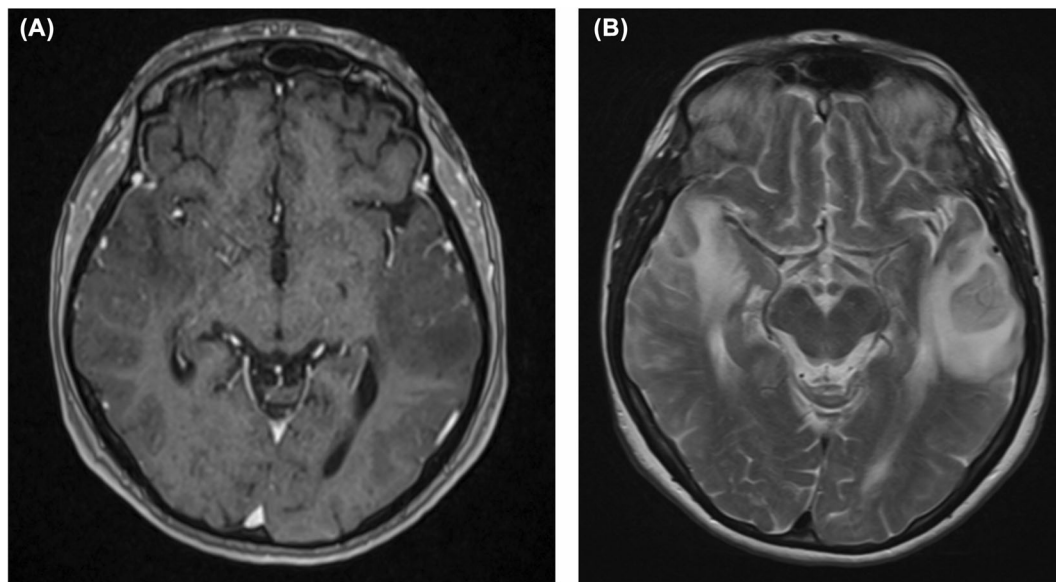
(A) ARIA MRI T1 axial (B) ARIA MRI T2 axial.
